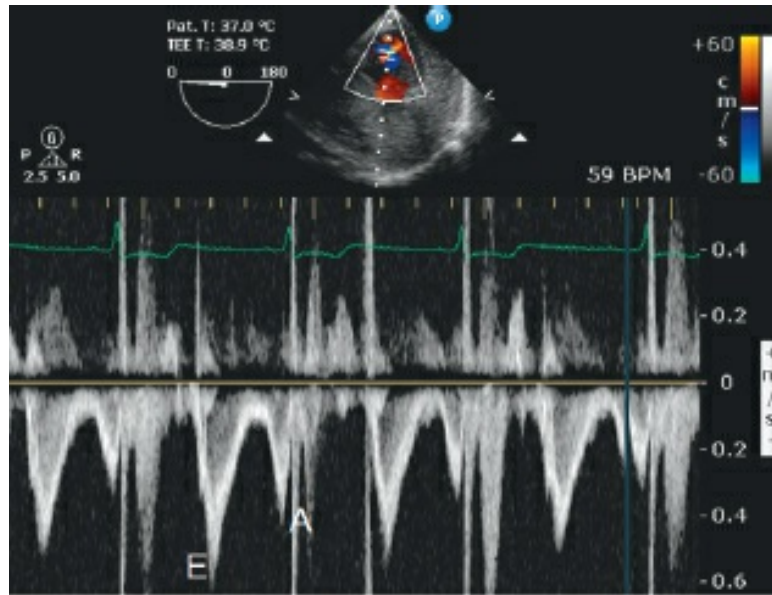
Trans-mitral flow on pulsed wave Doppler in a patient with normal left ventricular function. Note the early diastolic filling (E) and late diastolic filling (A) waves, with a normal E/A ratio (> 1)
